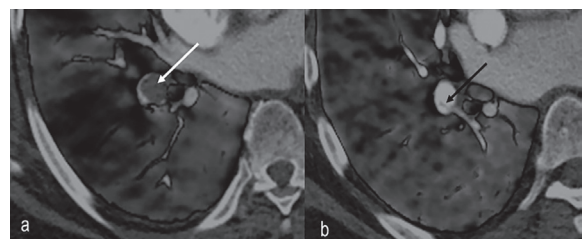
Image of pulmonary artery thrombosis. Initial evaluation with dual-energy CT shows a right lower lobe embolism (arrow) with pulmonary peripheral perfusion defect (a). Photographs taken
